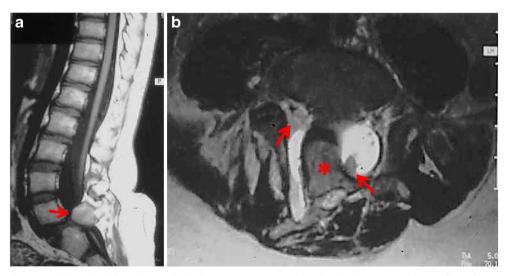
a, b Closed NTD—split cord malformation. a Sagittal T1 MRI scan of the lumbosacral spine. The *arrow* points to the bony spur that splits the spinal cord with each hemicord encased within its own dural sheath. b Axial T2 MRI scan of the same patient as shown in a. The
